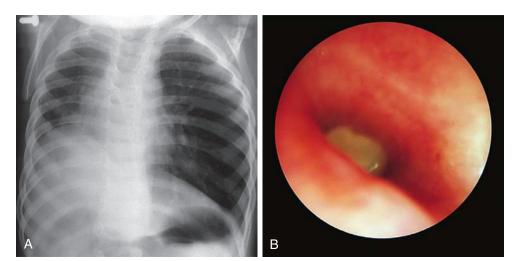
Foreign body aspiration—delayed presentation. A, With delay in presentation of partial obstruction or with complete obstruction of a bronchus, radiographic findings consist of atelectasis and a mediastinal shift *toward* the side of the foreign body. B, In this case a peanut was found completely obstructing the bronchus. (Courtesy Robert Gochman, MD, Schneider Children's Hospital, Long Island Jewish Medical Center, New Hyde Park, N.Y.)
